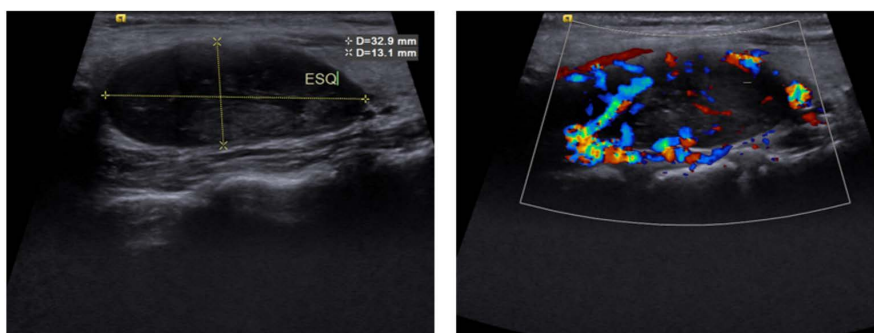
Parathyroid ultrasound. Ultrasound of the thyroid and parathyroid showing a solid and hypoechoic lesion in a superior and posterior topography to the left lobe of the thyroid, measuring 15 \times 13 \times 33 mm and highly vascularized on Doppler evaluation, suggestive of a parathyroid adenoma.
